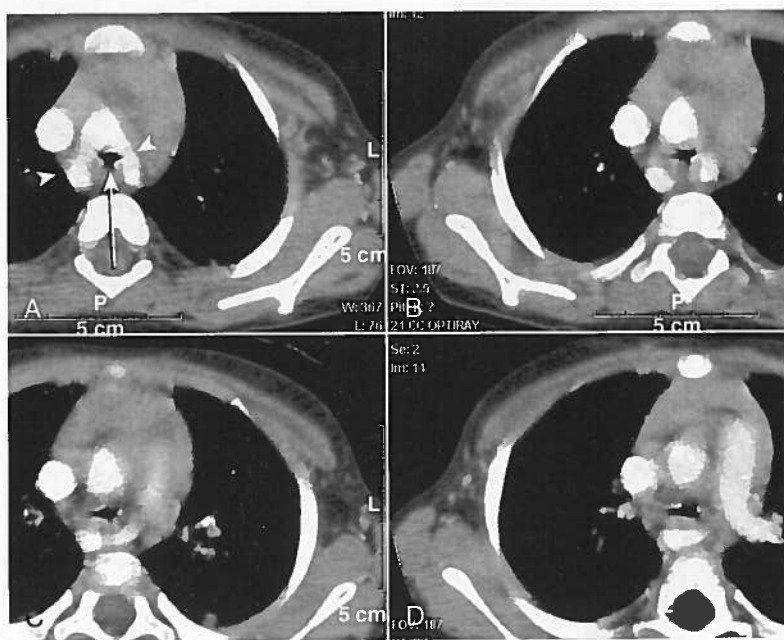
Lymphoma causing compression of the trachea. CT shows a large anterior mediastinal mass with posterior displacement and severe compression of the trachea (*white arrow*). The superior vena cava is also compressed (*black arrow*). There is a small amount of right pleural thickening.
